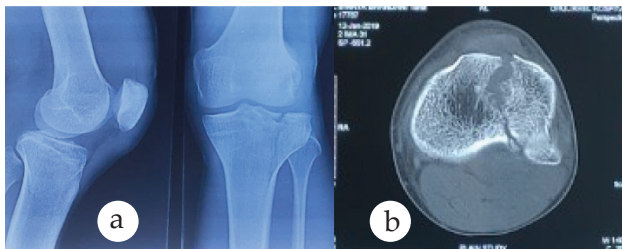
(a) X-ray (b) CT scan showing type I tibial plateau fracture in a 25 years male following fall on level ground (c) 3 year post-operative X-ray (d) Functional outcome of patient at 3 years post-operative period.
